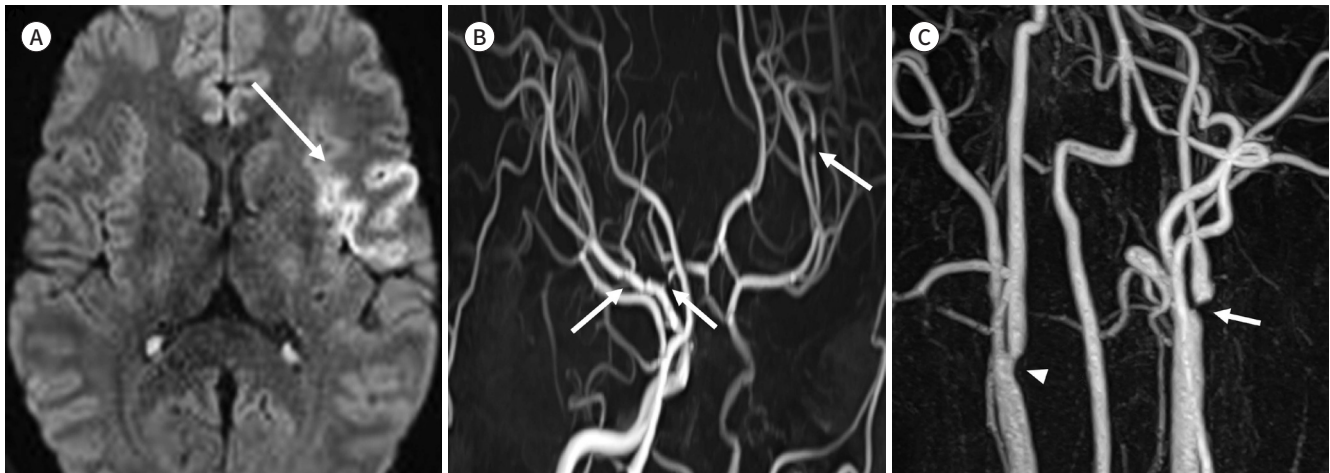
Carotid vessel wall MRI of acute cerebral infarction caused by polycythemia vera in a 30 year-old male.
